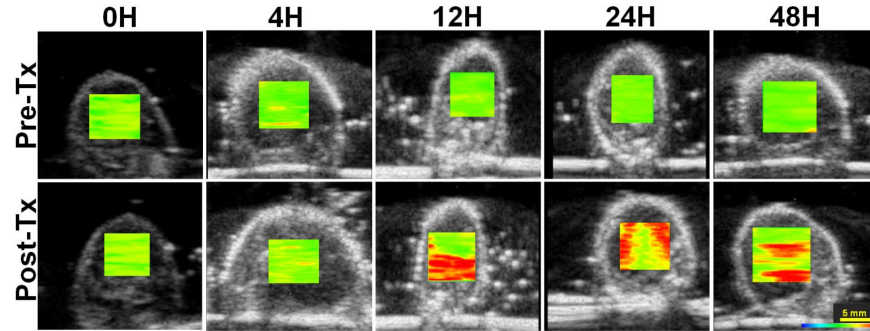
Representative ultrasound B-Mode images with ROI parametric overlays of the 0-MHz intercept.
